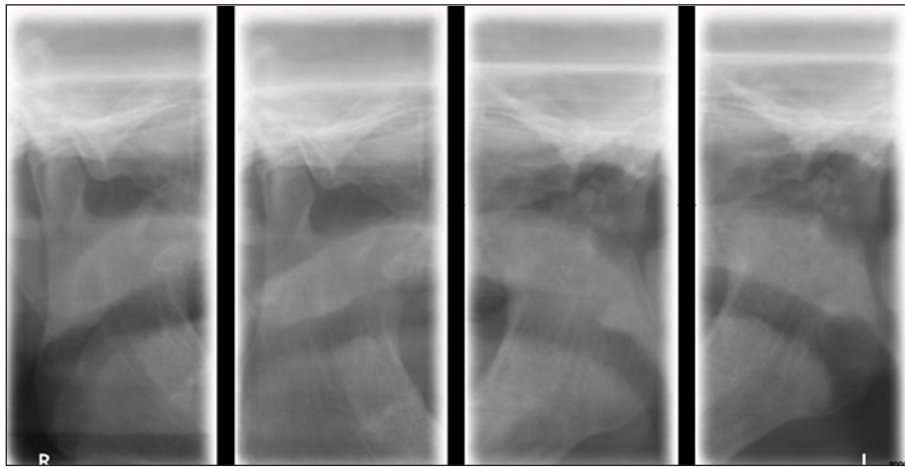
Radiograph of temporomandibular joint shows lytic appearance of left condyle one month after fracture.
